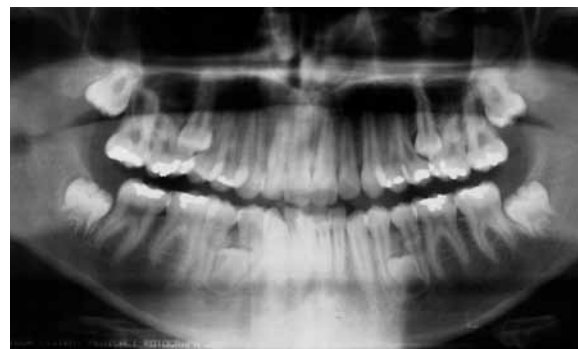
Panoramic radiograph used in orthodontic treatment (2005).
